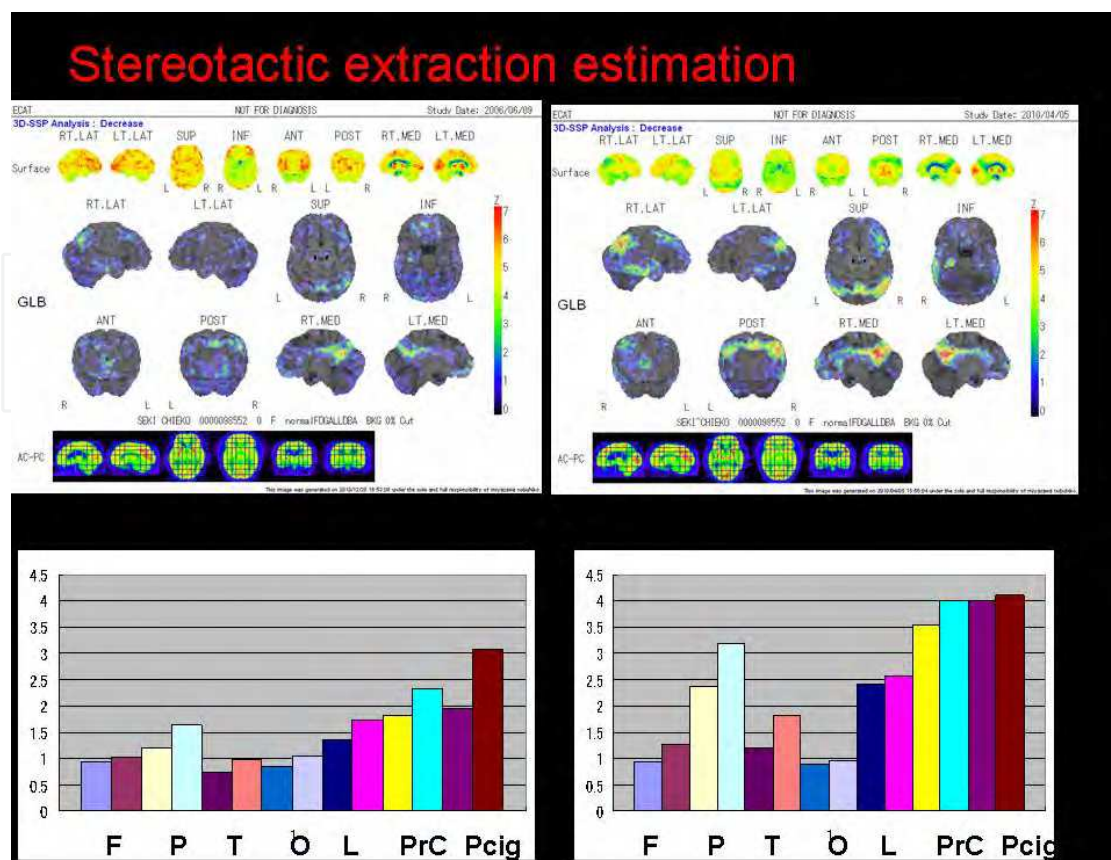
Longitudinal study of FDG-PET in AD.
